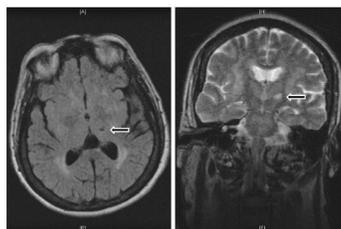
Axial T2 FLAIR MR image (left panel) showing a chronic left thalamic infarction (arrow). A T2 coronal image (right panel) demonstrates the postero-lateral thalamic location of the infarct.
